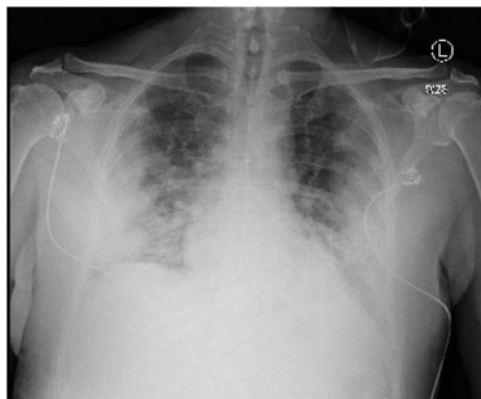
Chest radiograph with bilateral pulmonary infiltrates.
